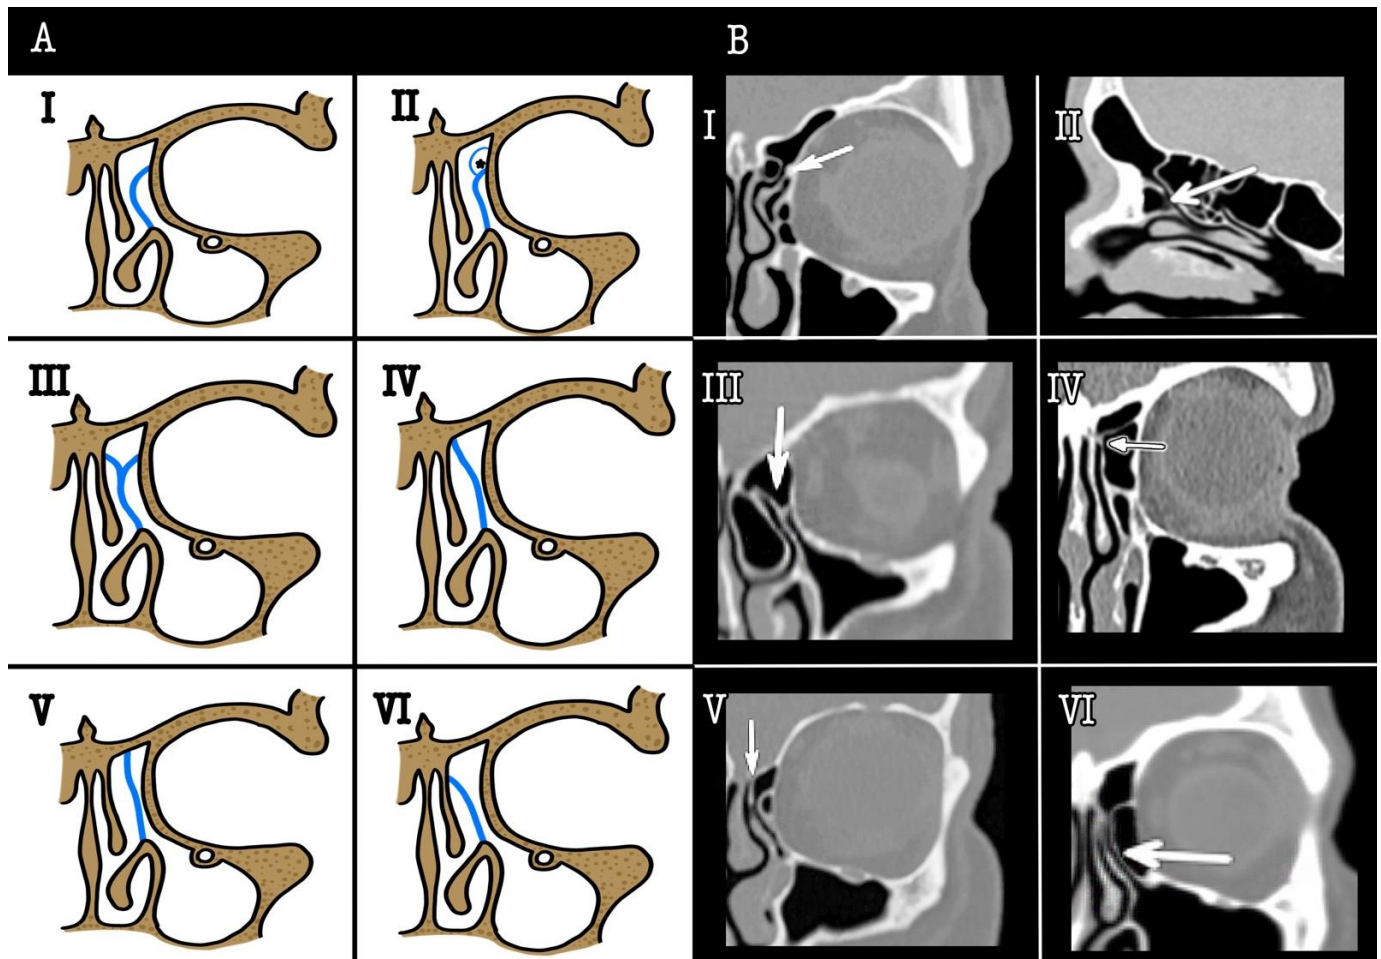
SAUP types (modified from Landsberg and Friedman (2001)). (A): graphical representation. Abbreviations: uncinete process in blue; asterisk (agger nasi cell). (B): CT scans. A white arrow shows the uncinete process superior attachment.
